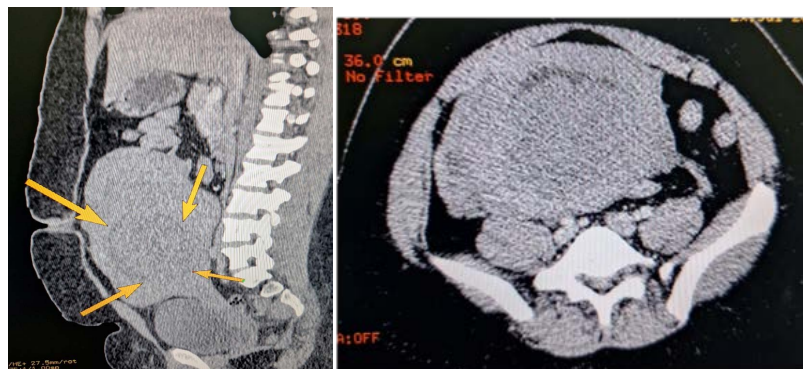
Abdominal CT scan; sagittal and axial reconstruction objectifying a mass related to polomyomatous globular uterus.
